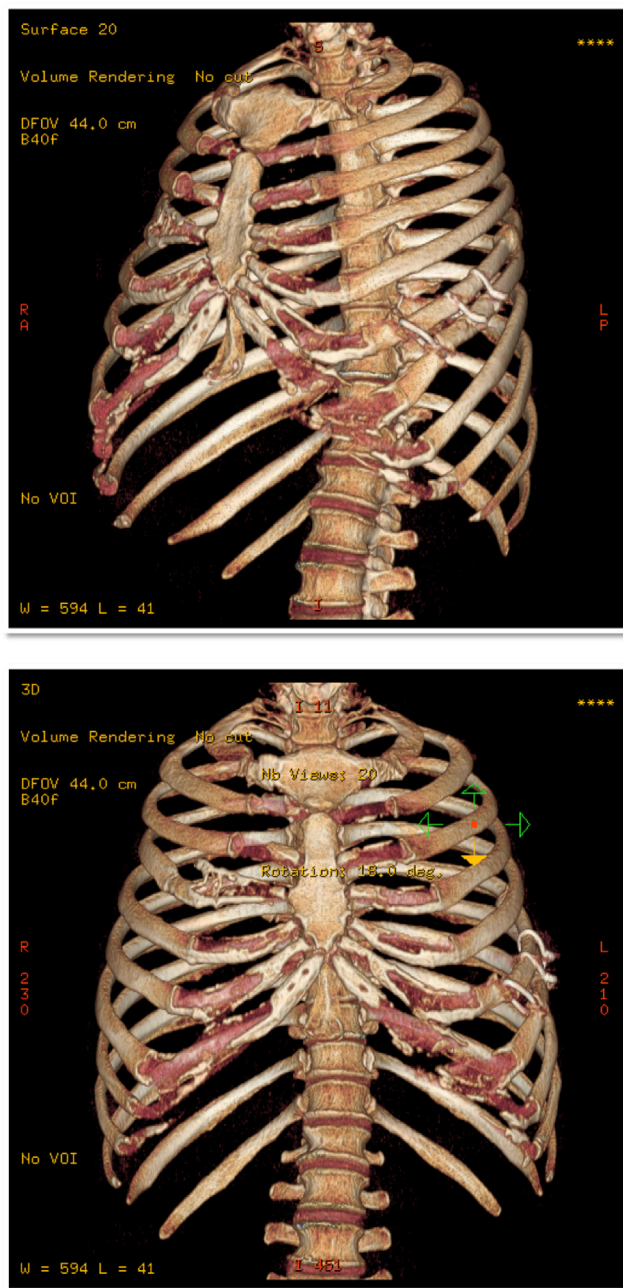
Initial CT scan showing lateral nonunion but inadequately visualizing costochondral nonunion in the medial aspect.
